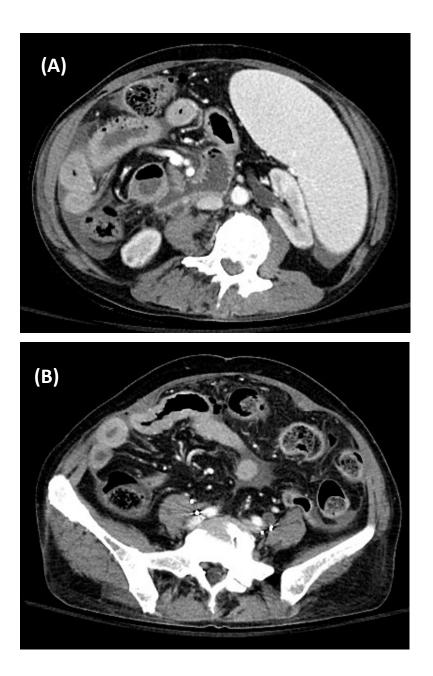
Abdominal CT of a 49-year-old woman with acute abdominal pain. (A) bowel wall thickening with intramural bowel gas, suspicious of bowel perfomation (B) bowel distention and Comb sign formation.
